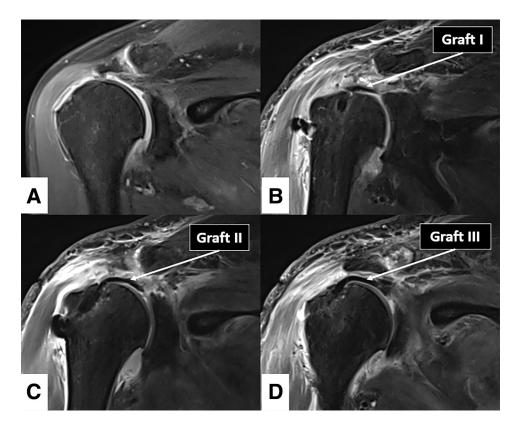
Oblique coronal view magnetic resonance imaging of right shoulder. (A) Preoperative view. (B, C, and D) Postoperative view indicating grafts I, II, and III, respectively.
